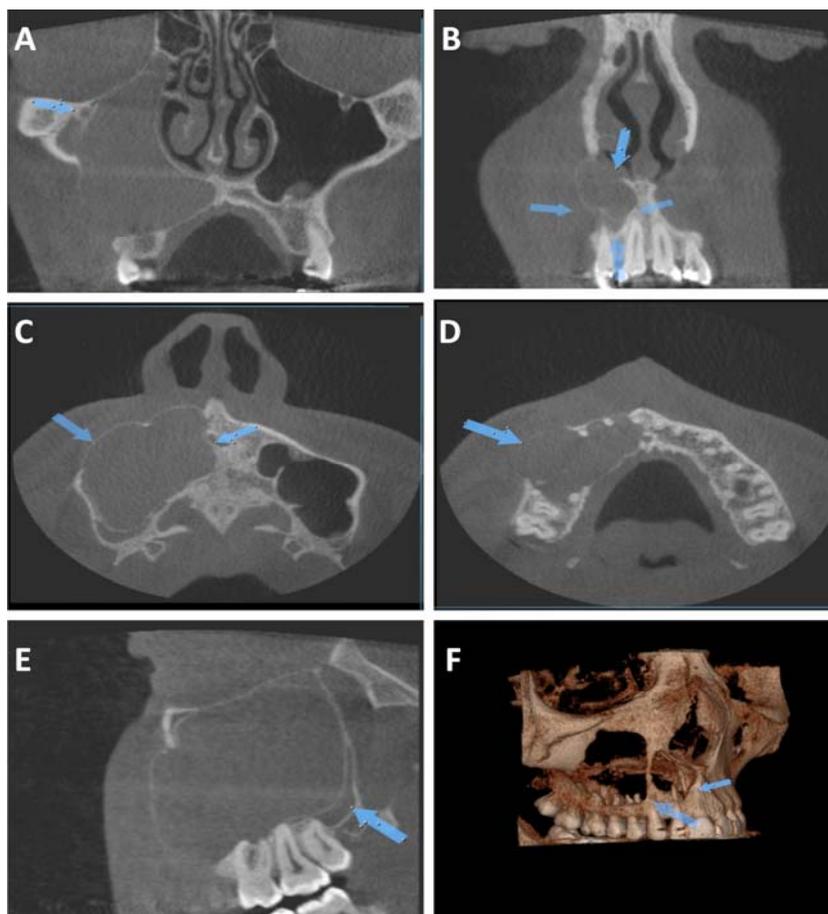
Cone-beam computed tomography (CBCT) scans of the radicular cyst in the maxillary sinus. A) The coronal view clearly shows the right maxillary sinus filled with cyst in the proximity to the infraorbital canal and the floor of the orbit; B) The coronal view shows growth of the cyst to the region of tooth 12; C) The axial view clearly shows the cystic lesion in the maxillary sinus, with thinning and perforation of the cortical plate on the medial aspect of the maxilla; D) The axial view clearly shows alveolar process of the maxilla deformity; E) The sagittal view of the maxilla shows the expansive lesion with posterior growth in the maxillary tuber; F) The 3D image of the affected site shows ovoid destruction of the bone.
